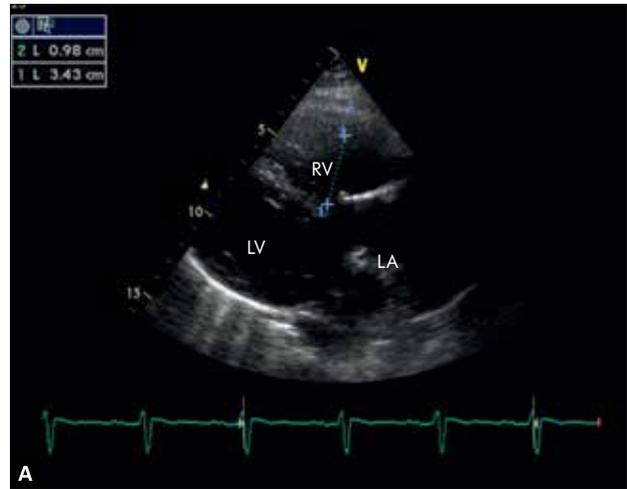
Transthoracic echocardiography. Parasternal long-axis view. M-mode imaging. Normal left ventricle function
